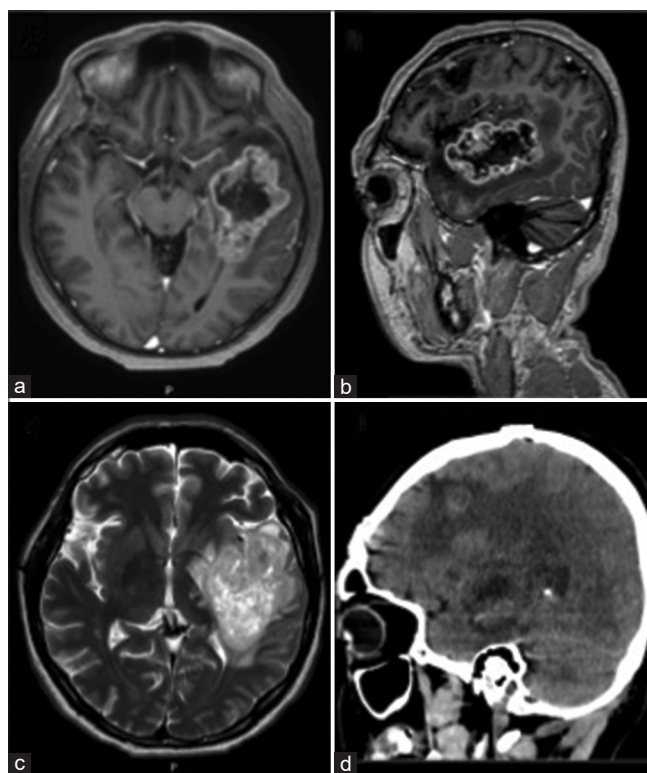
(a and b) Contrast-enhanced T1-weighted axial and sagittal magnetic resonance imaging (MRI) showing extensive tumor recurrence within the temporal lobe and deep structures; (c) T2-weighted axial MRI; (d) 10-h postoperative tomography showing tumor resection area.
